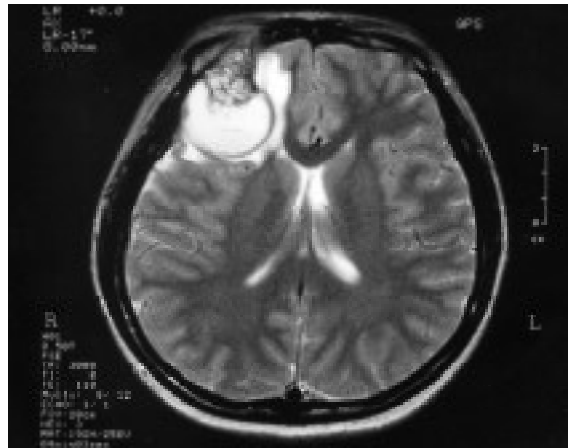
Axial T2-weighted MR image.
